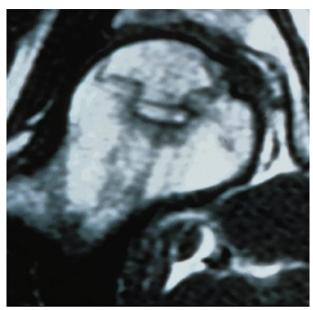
MRI for the diagnosis of FH ON
